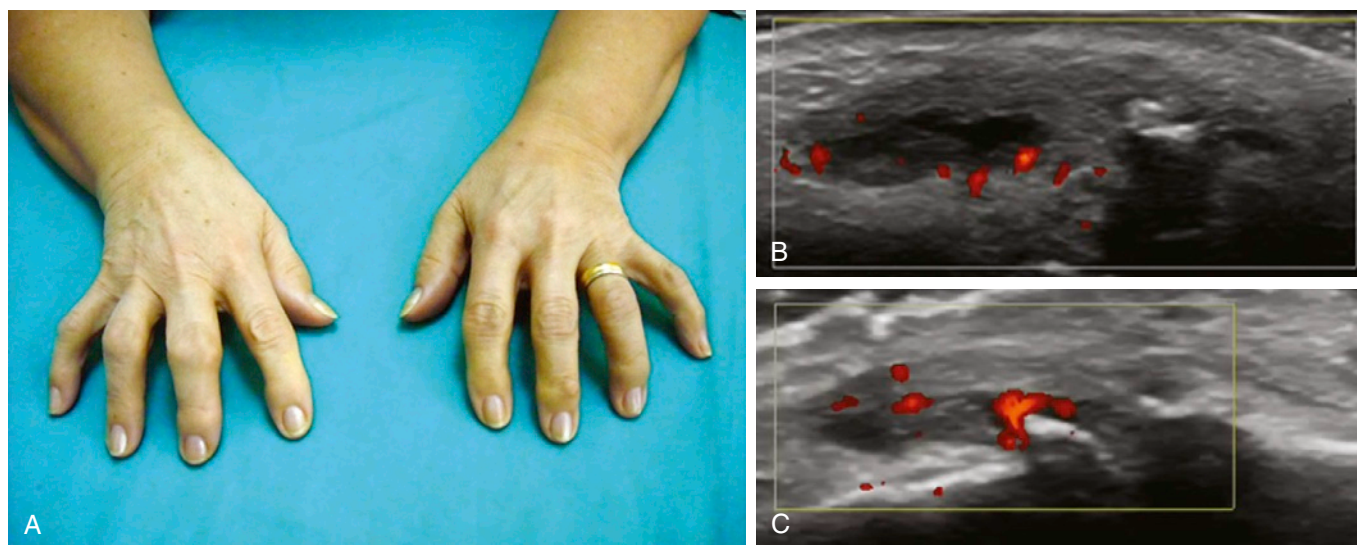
A, Ultrasound is used to examine the hands of a patient with osteoarthritis and inflammation of Heberden's nodes. B and C, Power Doppler confirms active inflammation in the distal interphalangeal joints by demonstration of an intra-articular Doppler signal due to hyperemic phenomena within the local synovial membrane.
